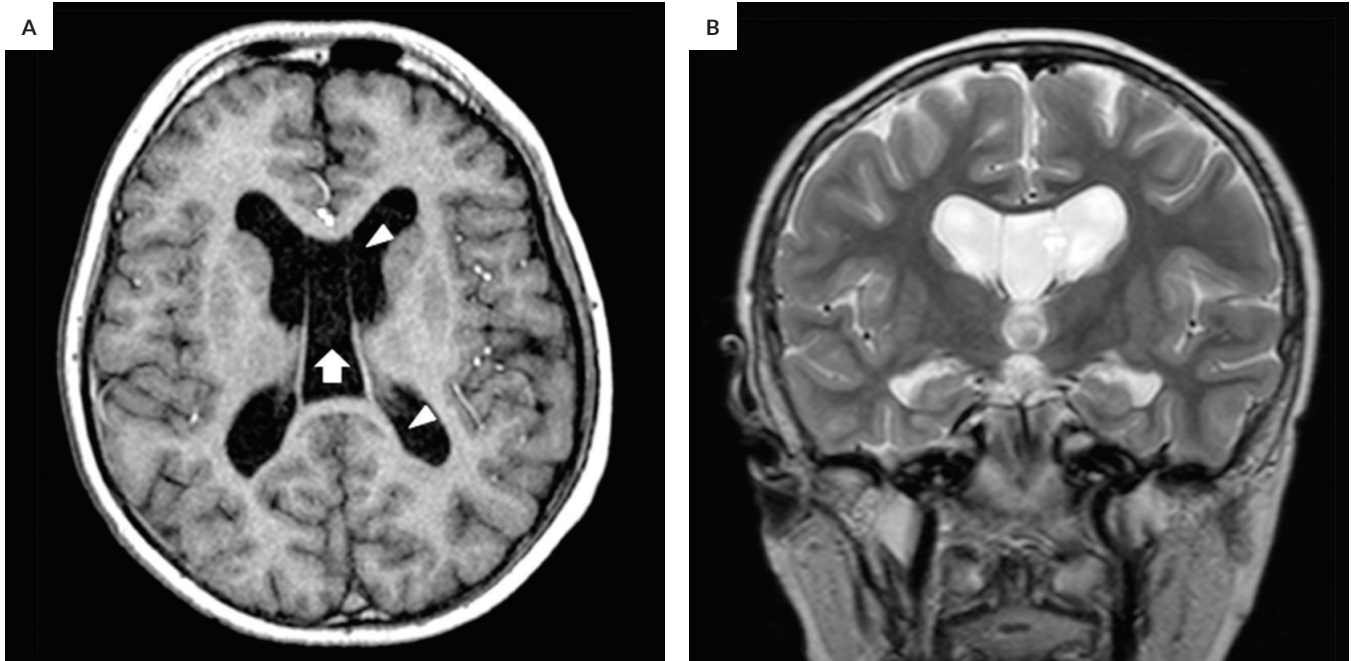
Cranial MRI of patient. (A) Axial T1 weighted image showing cavum septum pellucidum (*arrow*) ventriculomegaly with prominent trigone and occipital horns (*arrow head*), corpus callosal dysgenesis, and (B) coronal T2 fluid attenuated inversion recovery-weighted images showing normal hippocampus and absence of heterotopia.
